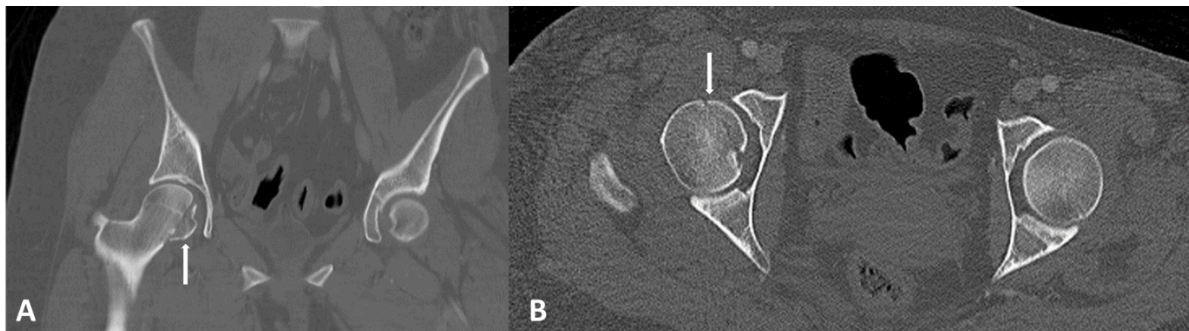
Post-reduction coronal (A) axial (B) CT images demonstrating successful reduction of right-sided posterior hip dislocation using the “Hamilton Deadlift”. A femoral head fracture (arrow) and the intact posterior wall of the acetabulum are also seen
